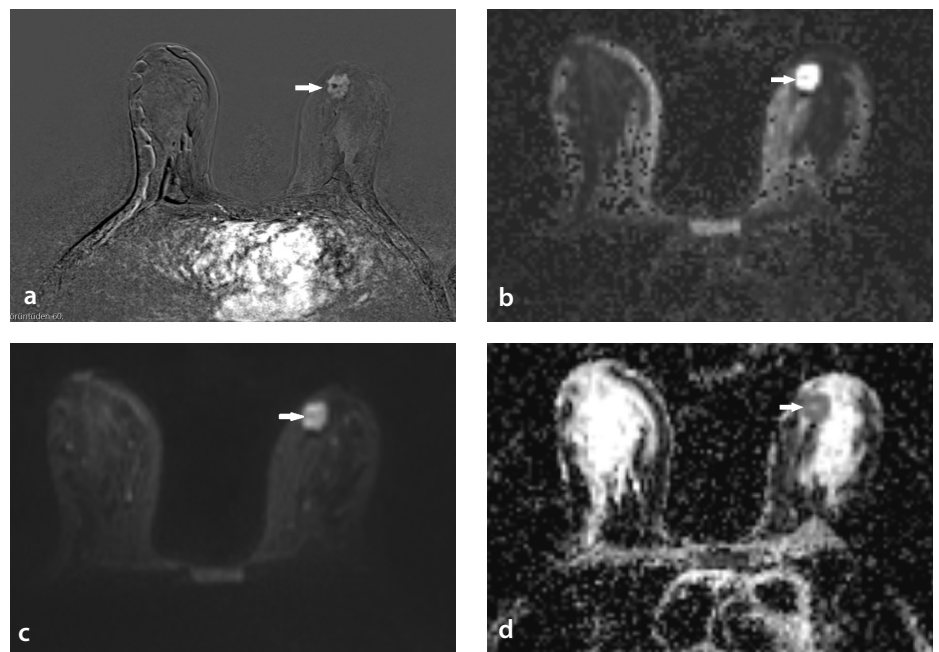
A 44-year-old female patient with a diagnosis of invasive ductal cancer in the inner part of the left breast. In the dynamic contrast-enhanced image (a), there is an irregular mass with heterogeneous enhancement. Synthetic diffusion-weighted image (b) showed markedly hyperintense mass, and conventional diffusion-weighted image (c, d) showed homogeneous diffusion restriction in the mass (hyperintense on DWI and hypointense on ADC map). The ADC values were measured at least three times. The average ADC value was 0.769×10^{-3} mm²/sec, which is below the cut-off value (1.189×10^{-3} mm²/sec). DWI, diffusion-weighted imaging; ADC, apparent diffusion coefficient.
